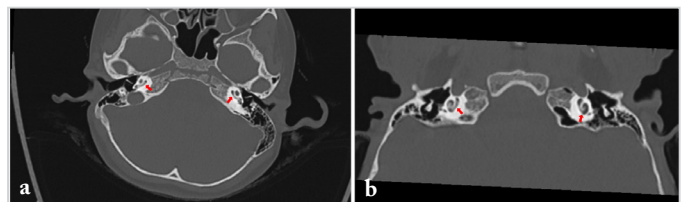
HRCT of temporal bones: a) axial cuts, and (b) coronal cuts showing mild ossification of basal turn and clear middle and apical turns bilaterally (red arrow)
